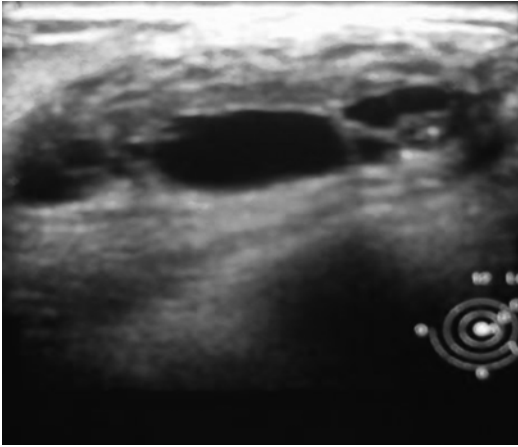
Benign axillary lymph nodes explored by ultrasound scan
